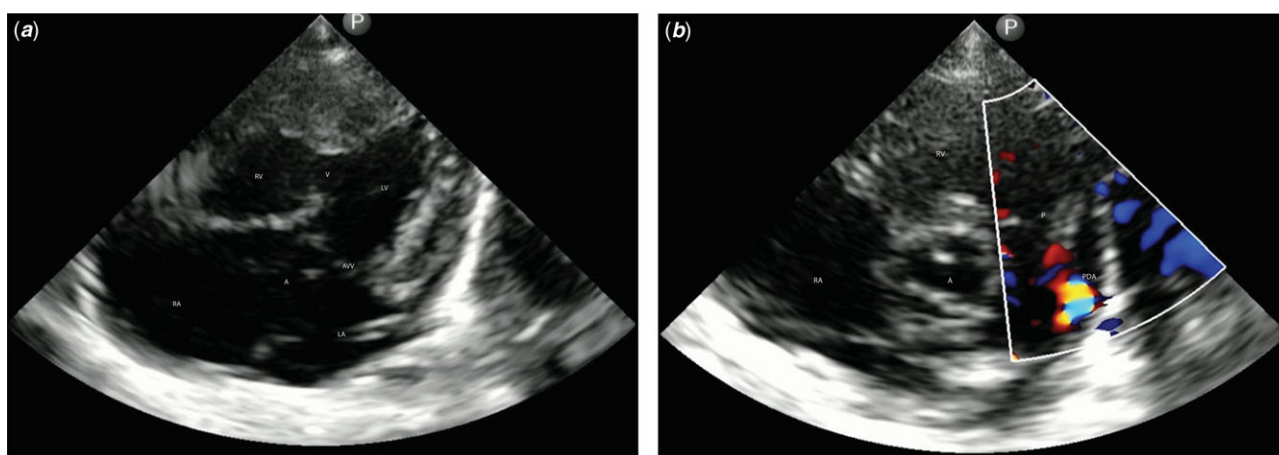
Unbalanced atrioventricular septal defect with small patent arterial duct in a 7-week-old with clinical features of Trisomy 21 and congestive heart failure symptoms (a) shows the apical four chamber view of an unbalanced atrioventricular septal defect with large atrial and ventricular septal defect components. RA - right atrium, RV - right ventricle, LA - left atrium, LV - left ventricle, A - atrial septal defect component, V - ventricular septal defect component of the atrio-ventricular septal defect, AVV - atrio-ventricular valve leaflets. (b) Shows unobstructed outflow tracts with a patent arterial duct shunting left to right in the same patient. RA - right atrium, RV - right ventricle, P - pulmonary valve/ right ventricular outflow tract, A - aortic valve, PDA - patent arterial ductal flow in color.
